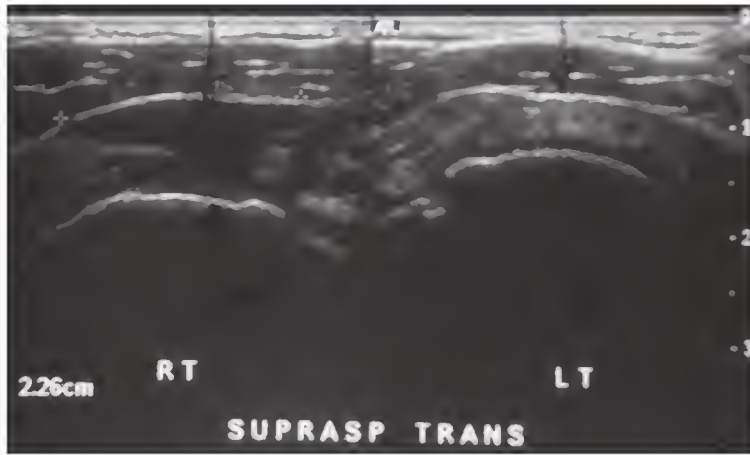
Ultrasound of an acute full-thickness rotator cuff tear.
